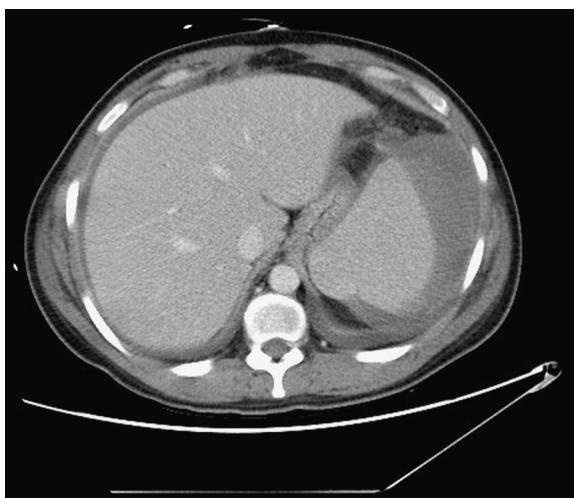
Computed topography (CT) scan of the abdomen and pelvis with IV contrast showing haemoperitoneum with blood clot adjacent to spleen suggestive of rupture.
